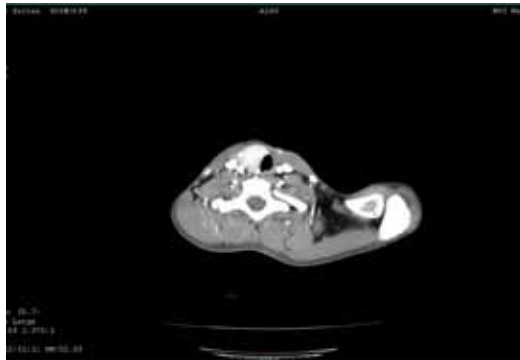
Contrast CT study at the same level as above showing homogeneously enhancing enlarged right thyroid lobe (arrow) and absent left thyroid lobe.
